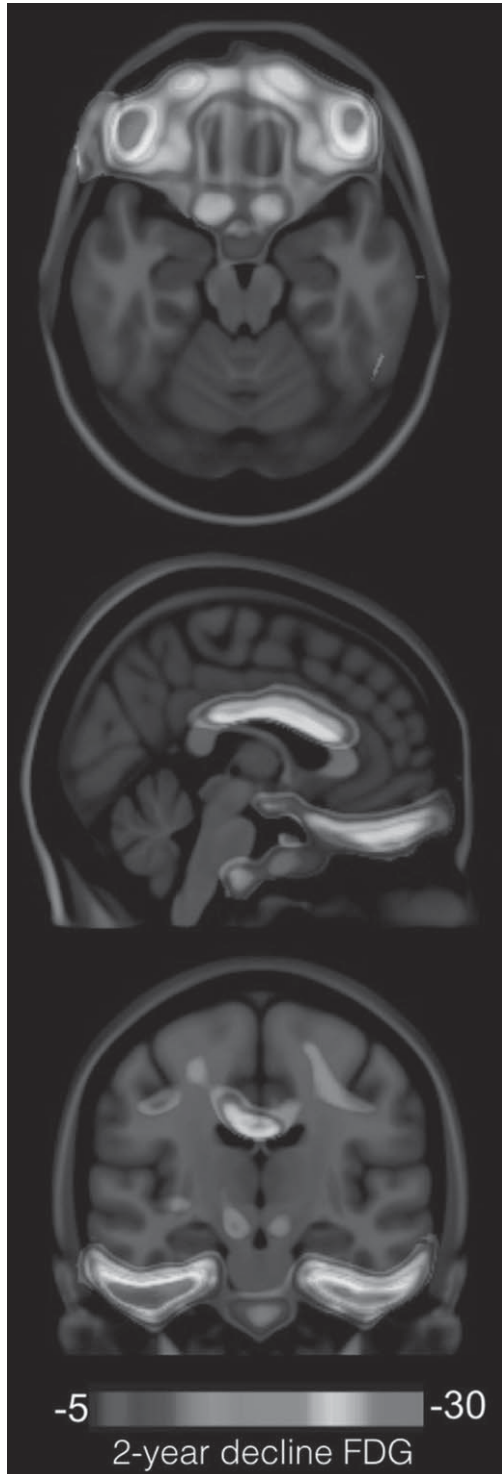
Brain regions vulnerable to the synergy between $A\beta$ and tau in cognitively normal persons. The parametric map, overlaid in a structural MRI, revealed regions where 2-year [^{18}F]FDG metabolic decline was associated with the synergistic effect between $A\beta$ and tau in cognitively normal elderly individuals.
